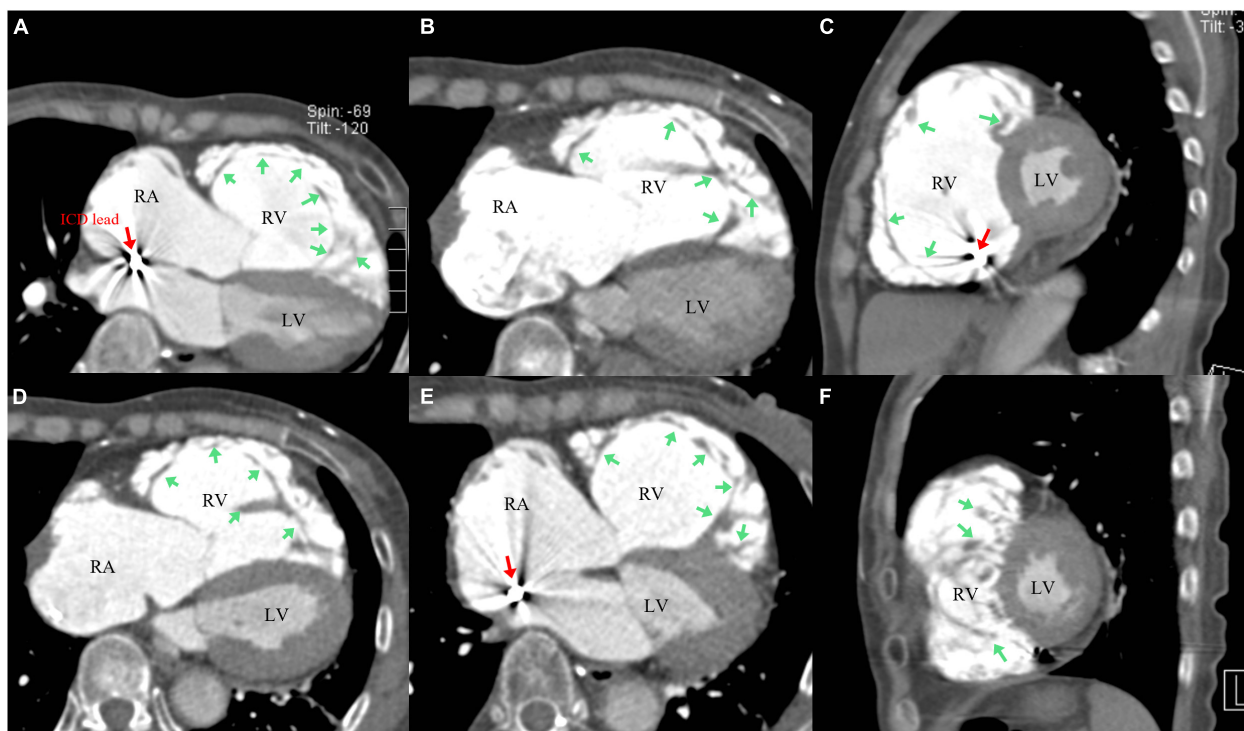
Contrast Computed tomography (CT) revealed abnormally dilated right ventricle (RV) and right atrium (RA), multiple protruding low-density intracardiac trabeculae attached to wall of the RV, and the high-density contrast agent in intertrabecular recesses and RV cavity (A–F) [green arrow: trabeculae (A–F); red arrow: ICD lead (A,C,E)]; The left ventricle (LV) myocardium is thickened, and the trabeculae is normal (A–F).
